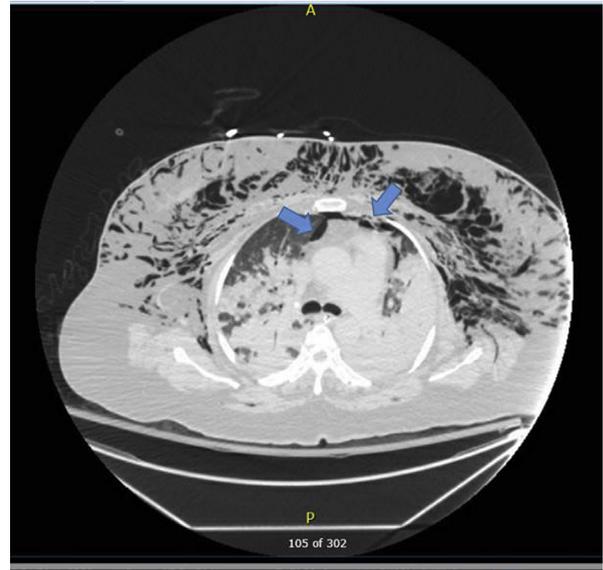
Computed tomography of the chest highlighting pneumomediastinum (arrows) in addition to the massive subcutaneous air.
